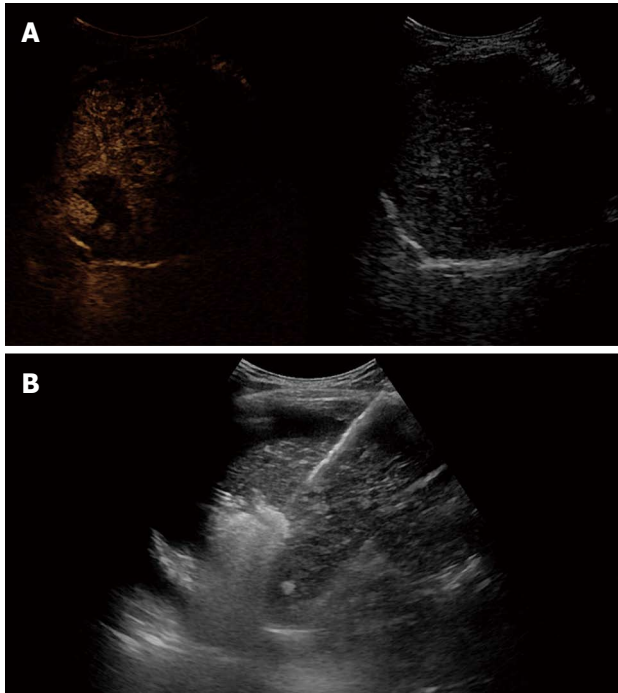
After confirming viable tumor by contrast enhanced ultrasound, radiofrequency ablation was performed. A: Contrast enhanced ultrasound revealed two arterial enhancing nodules in tumor; B: Percutaneous ultrasound guided radiofrequency ablation was performed for residual viable tumor by inducing artificial ascites.
